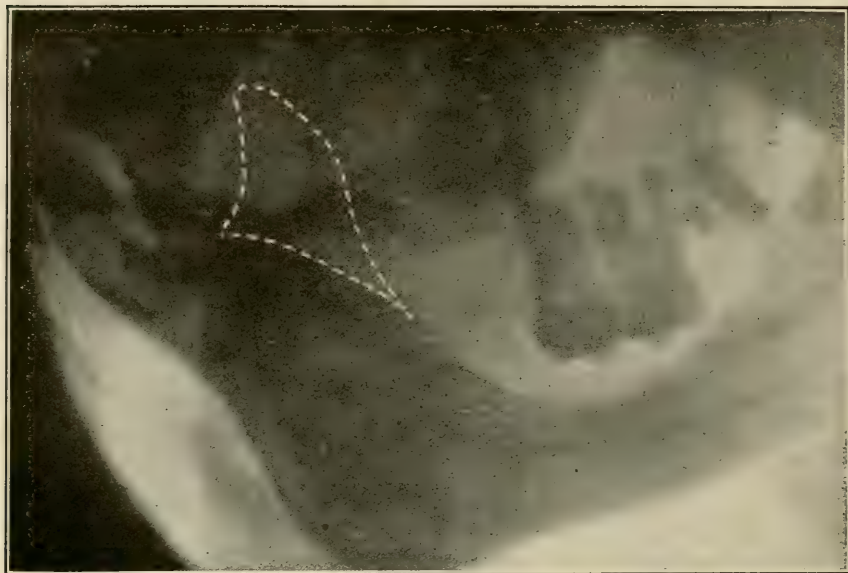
The dots outline the missing parts—i.e., the anterior border of the ramus and the coronoid process. (Radiograph by Cole and Raper.)
